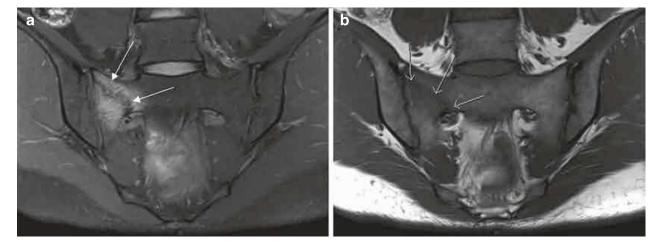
MRI views of sacral stress fracture (white arrows) on STIR (a) and T1 (b)
